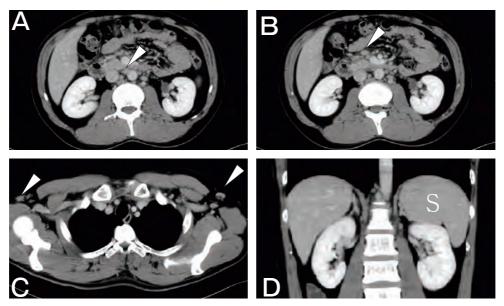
Contrast-enhanced CT scan revealed enlarged lymph nodes at the para-aortic ((A), 12 mm), mesenteric ((B), 13 mm), and axillary regions ((C), 15 mm) (arrowheads), as well as splenomegaly ((D), 12.5 cm; indicated by S).
